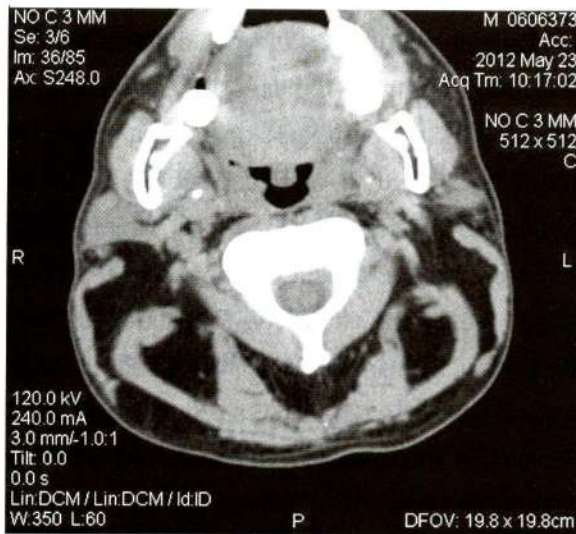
Axial non-contrast CT scan showed thinning of sternocleidomastoid muscles and paraspinal muscles with symmetrical fatty infiltration.
